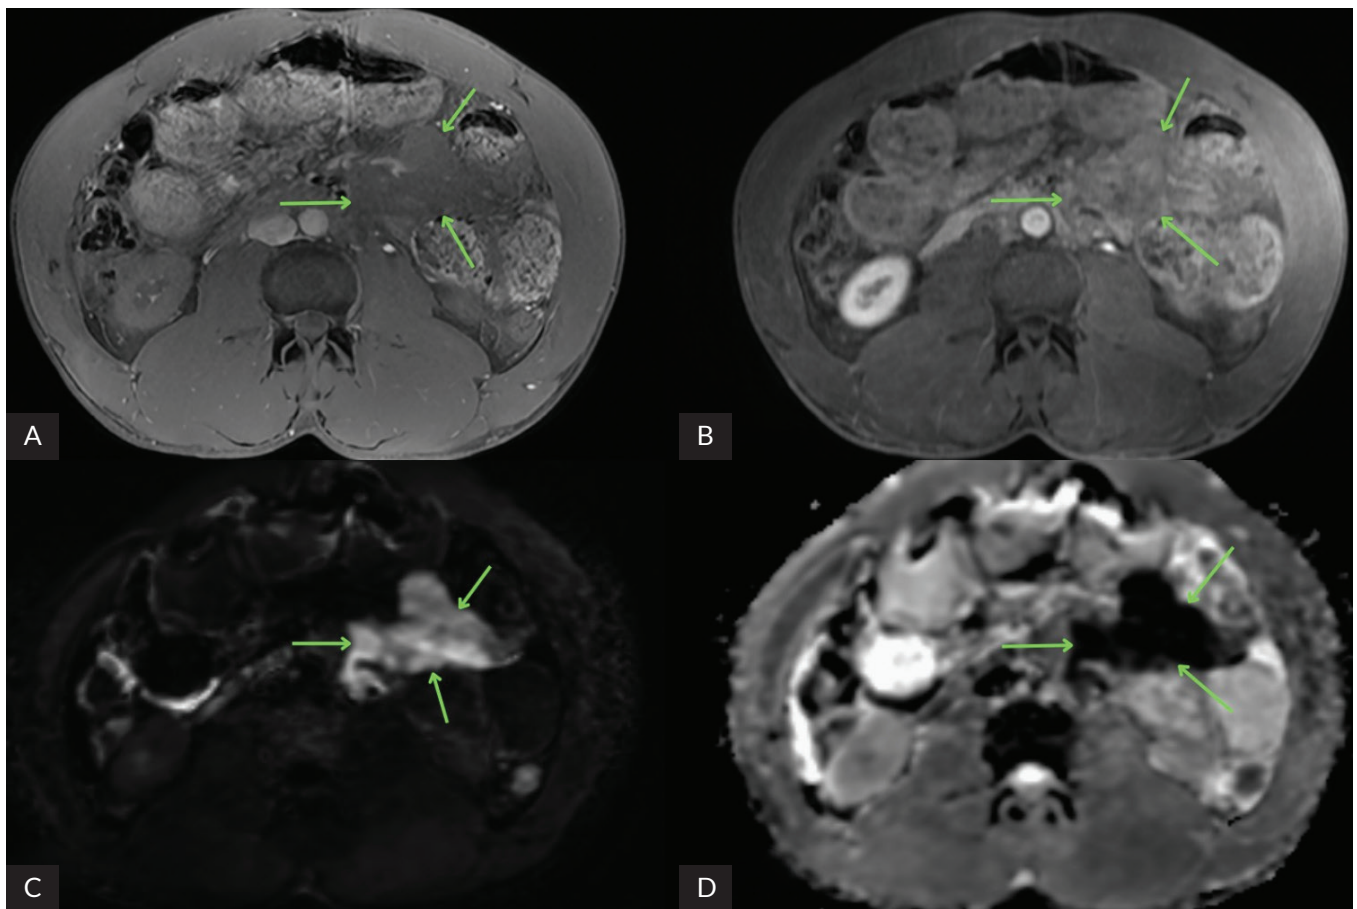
Selected transverse abdominal MRI scans show a lymphoma in the left mesentery of the small intestine (indicated by arrows). A. Pre-contrast T1-weighted image with fat suppression; B. Post-contrast T1-weighted image with fat suppression; C. DWI image; D. DC map
